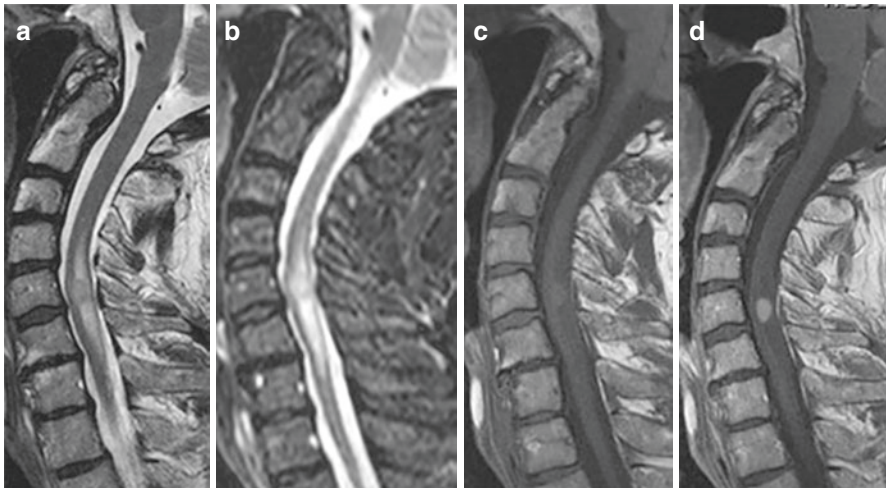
Spinal cord metastases. Sagittal T2-weighted (a), STIR (b), T1-weighted (c), and contrast-enhanced T1-weighted (d) images. Well-defined oval mass in the cervical spinal cord, hyperintense in T2 and STIR, isointense to spinal cord on T1-weighted image; homogeneously enhancing after contrast administration
